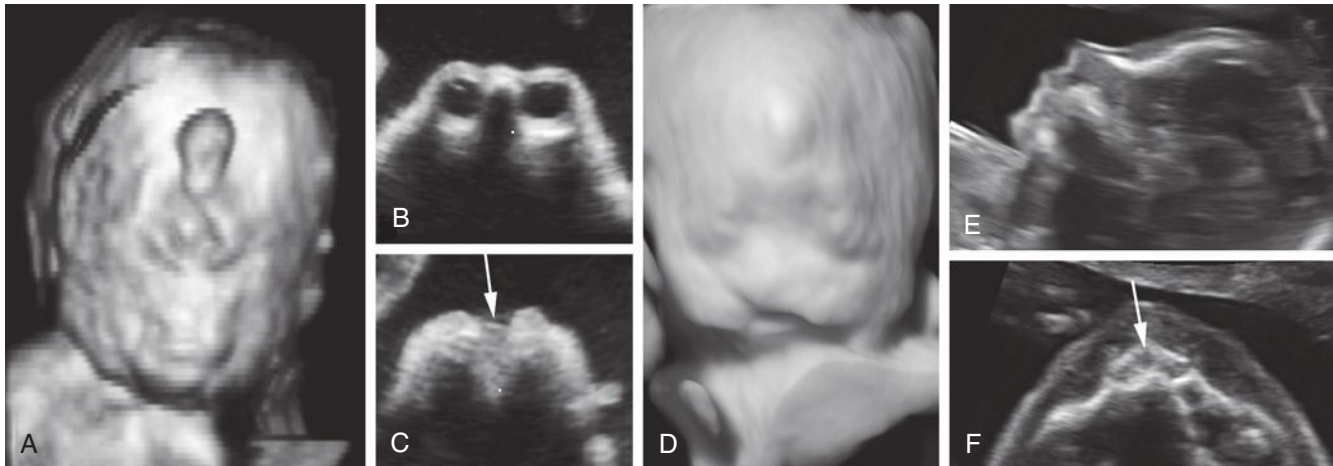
Facial anomalies associated with holoprosencephaly. A, Three-dimensional ultrasound image of cyclopia, with proboscis protruding above the single orbit; B through D, marked hypotelorism and median cleft lip (*arrow*); E and F, subtle facial features of holoprosencephaly—although the midline sagittal profile view appears normal, meticulous scanning reveals a single median incisor tooth (*arrow*).
